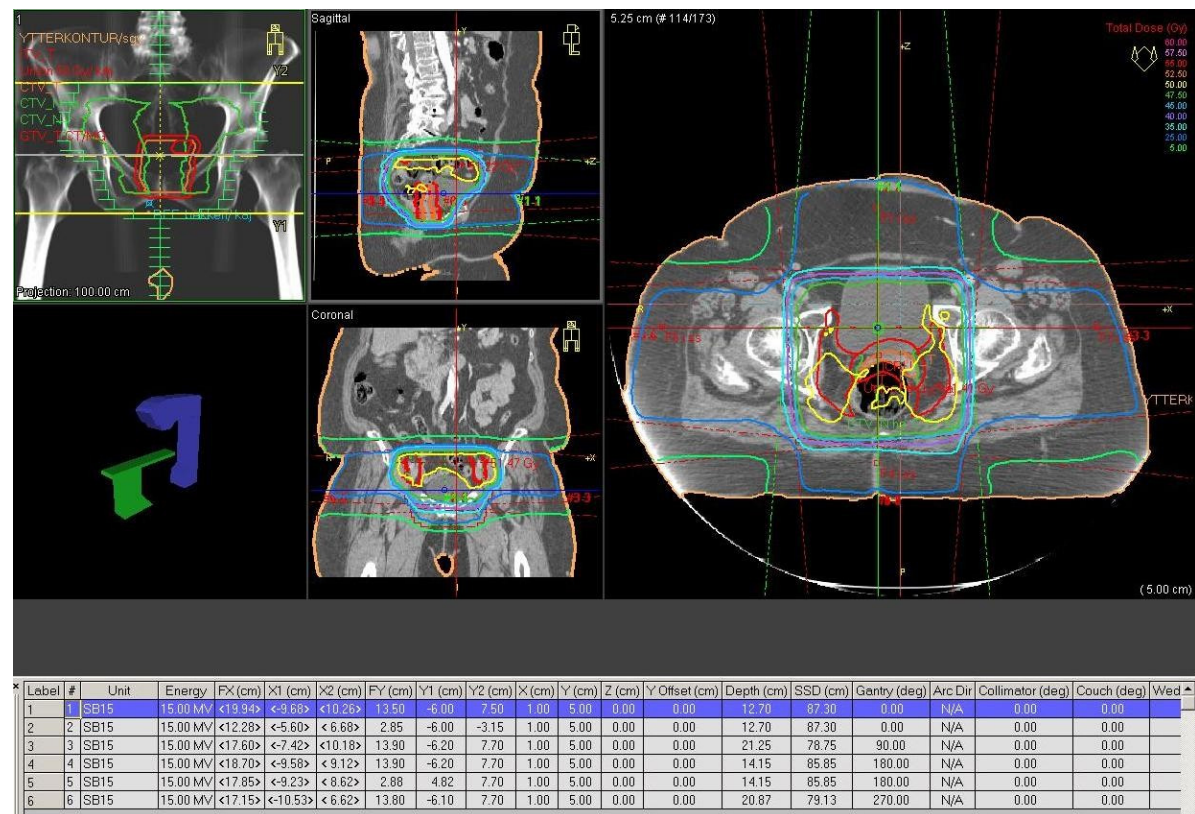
A typical “box-field” being planned from a CT-scan in a computer-program designed for radiotherapy [22].
